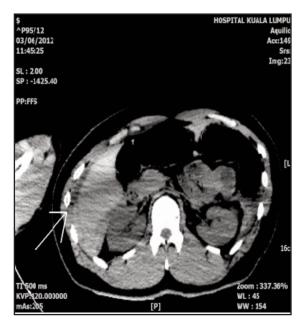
Axial view of plain post mortem CT scan of a patient showing perihepatic haematoma (arrow) at the inferior margin of the right liver. Some parts of the liver margin lost its smooth delineation and were irregular.
